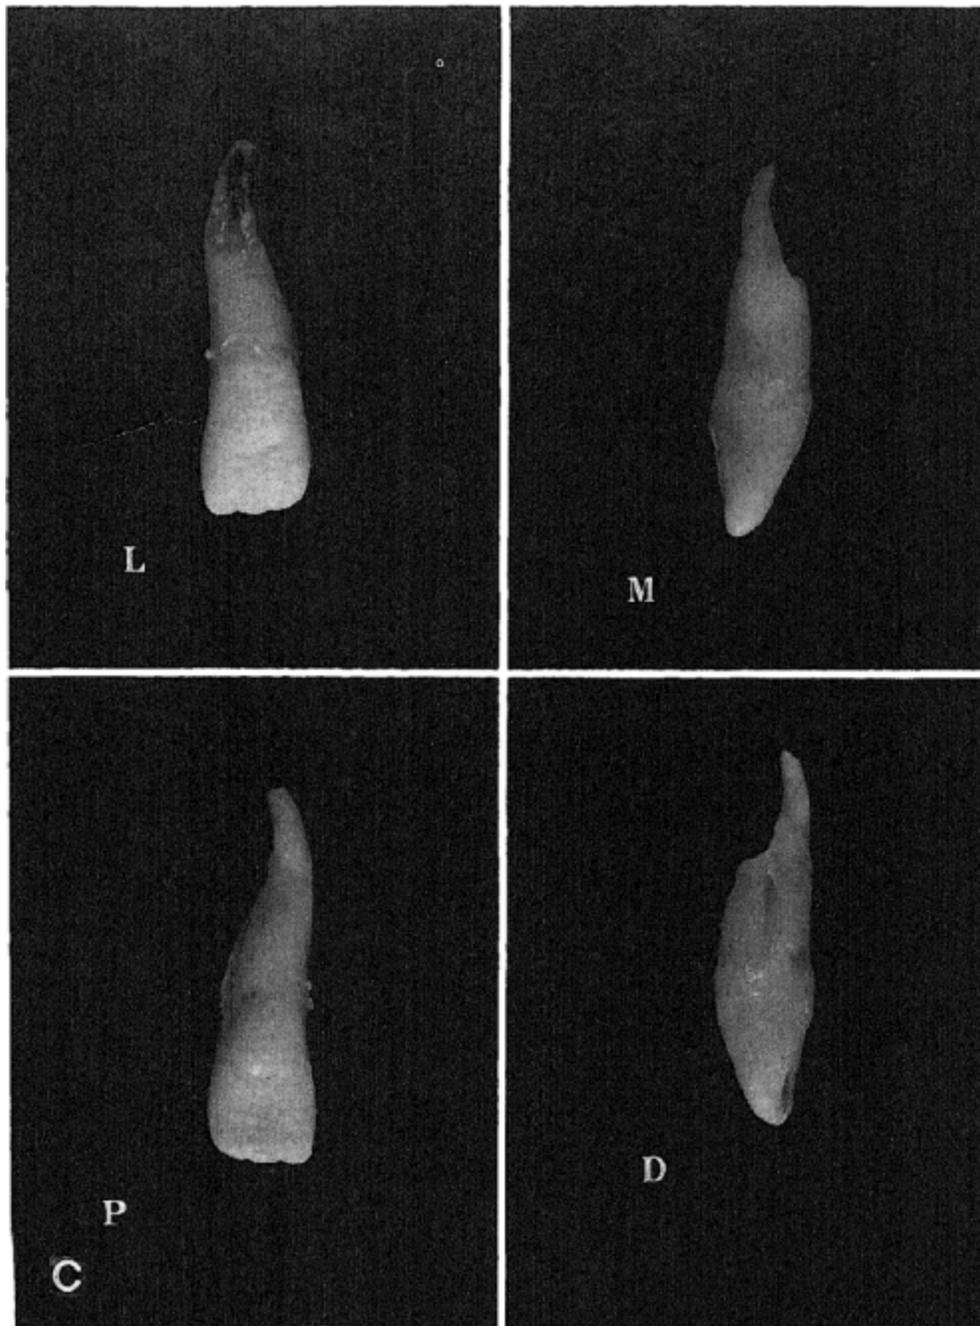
Labial (L), mesial (M), palatal (P), and distal (D) aspects of extracted left maxillary lateral incisor. Note the severe root resorption and its tortuous pattern which could not be detected on the periapical roentgenogram.
